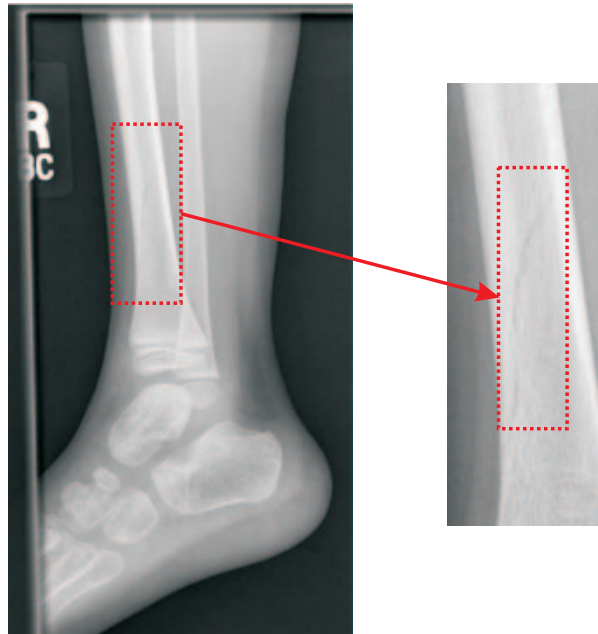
Infant's Fracture. This typically occurs in young children as a spiral hairline fracture often invisible on initial radiographs. Diagnosis can be verified if pain is reproduced with the application of torque stress across the fracture. The fracture can be seen within the dotted square.
